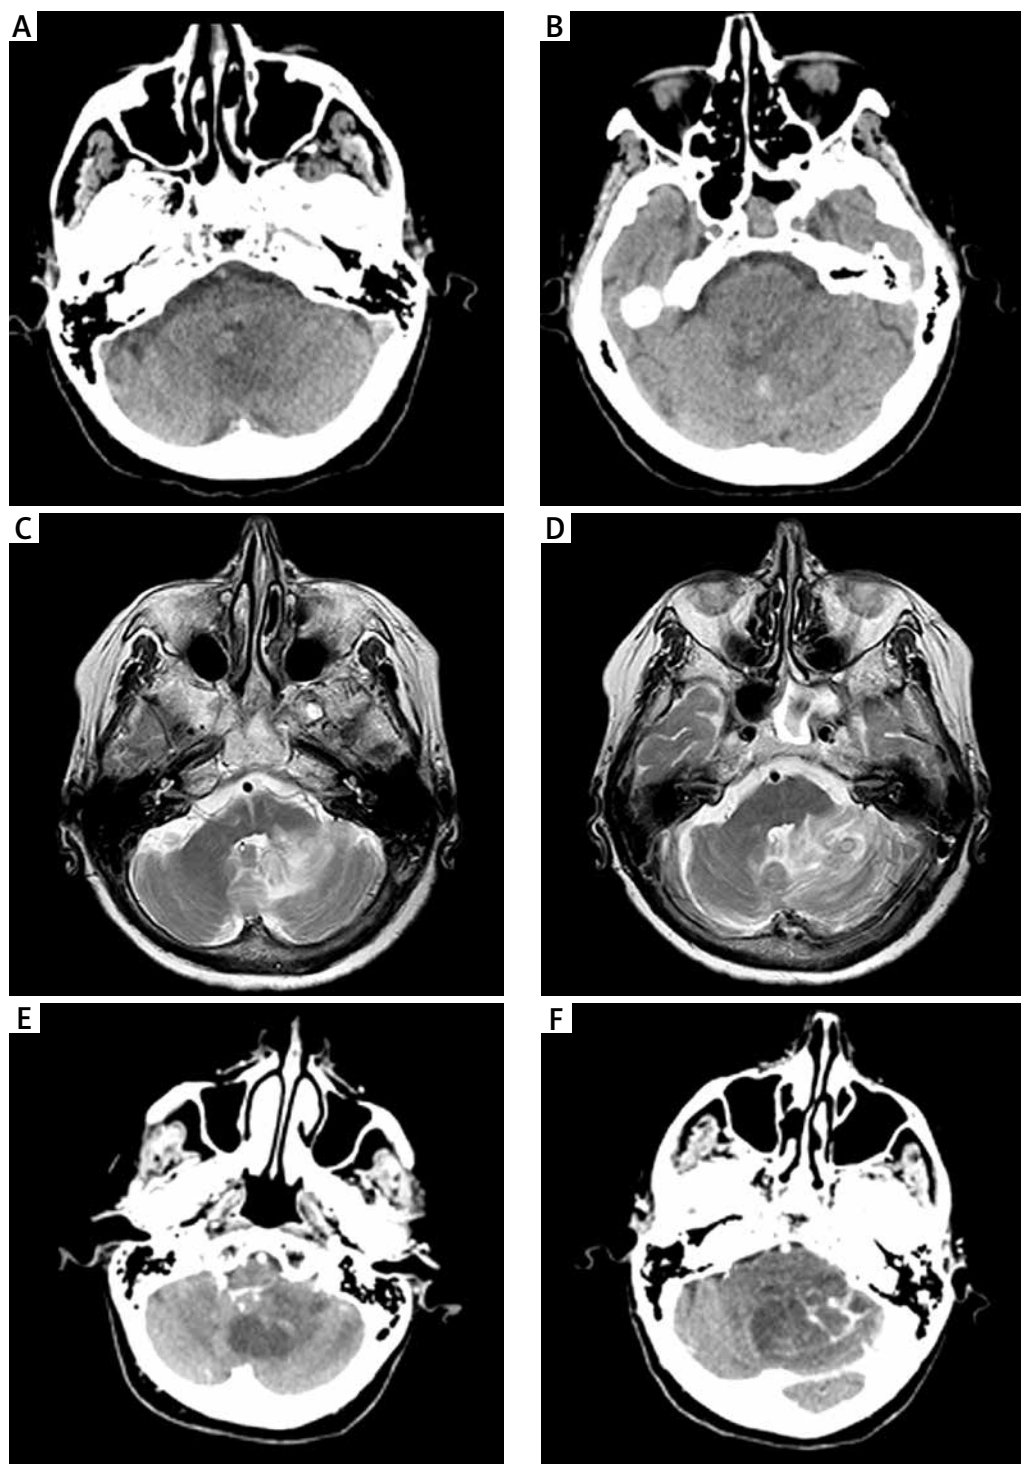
A-B) Cerebral computed tomography (CT) on the 39th day of clinical course. Note the large hypodensity in the left paravermian region, partially extending to the right side, with a hyperdense area in its context. C-D) Cerebral magnetic resonance imaging (MRI) on the 43rd day showing T2 flair hyperintense area in the superior portions of the left cerebellar hemisphere, partially extending to the vermis and right paravermian region; a GE T2 hypointense area is also visible. E-F) Cerebral CT on the 55th day, more clearly showing the cerebellar lesion as a voluminous hypodense area with foci of intense contrast impregnation.
